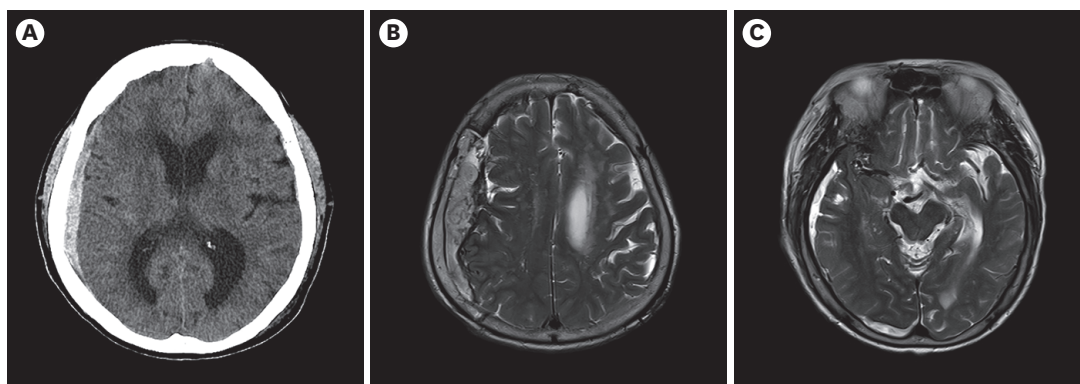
Brain CT and MRI demonstrate a right fronto-temporo-parietal subdural hematoma. (A) Initial brain CT (axial). (B) Brain T2-weighted MRI (axial) without parenchymal lesion. (C) Brain T2-weighted MRI (axial) without midbrain lesion. CT, computed tomography; MRI, magnetic resonance imaging.
